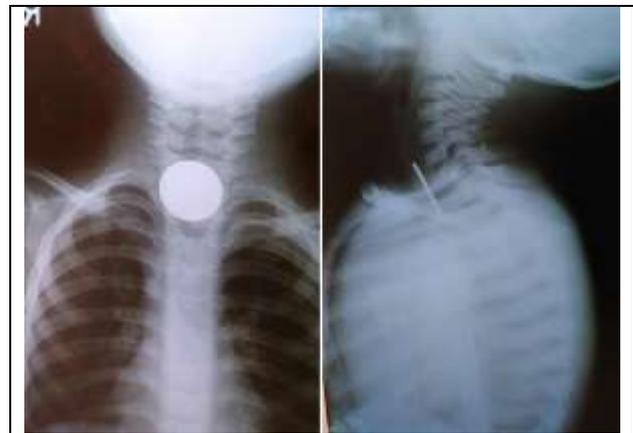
X-Ray Neck Soft Tissue Anteroposterior and Lateral View Showing FB (Coin) in Cricopharynx
